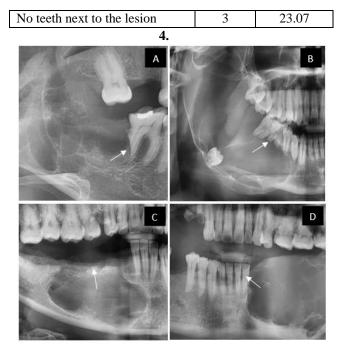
Cropped the OPG radiograph showing effect ameloblastoma on dentition; A: Root resorption only; B: Both root resorption and root/tooth displacement; C: No teeth next to the lesion, and D: No effect
